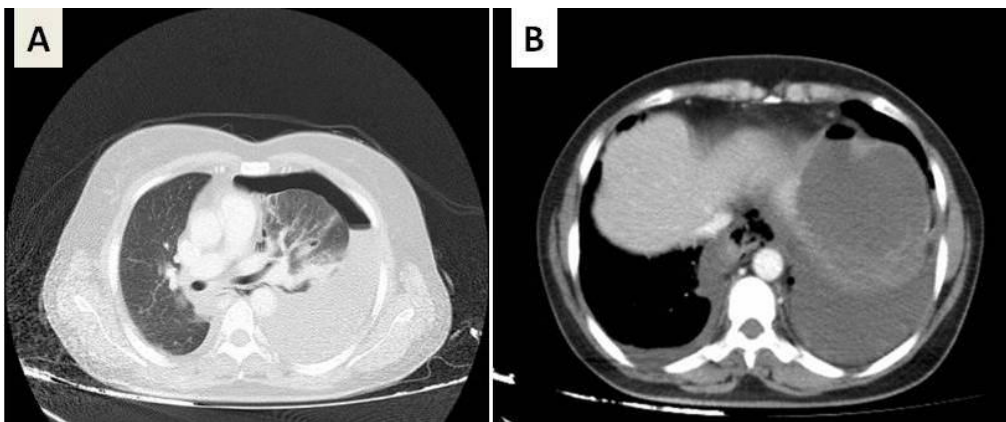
Thoracic computerized tomography (CT): A: Showed left-sided pneumothorax, pneumomediastinum, distal paraesophageal air-fluid densities and rightward mediastinal shift, B: Bilateral pleural effusion with left predominance
